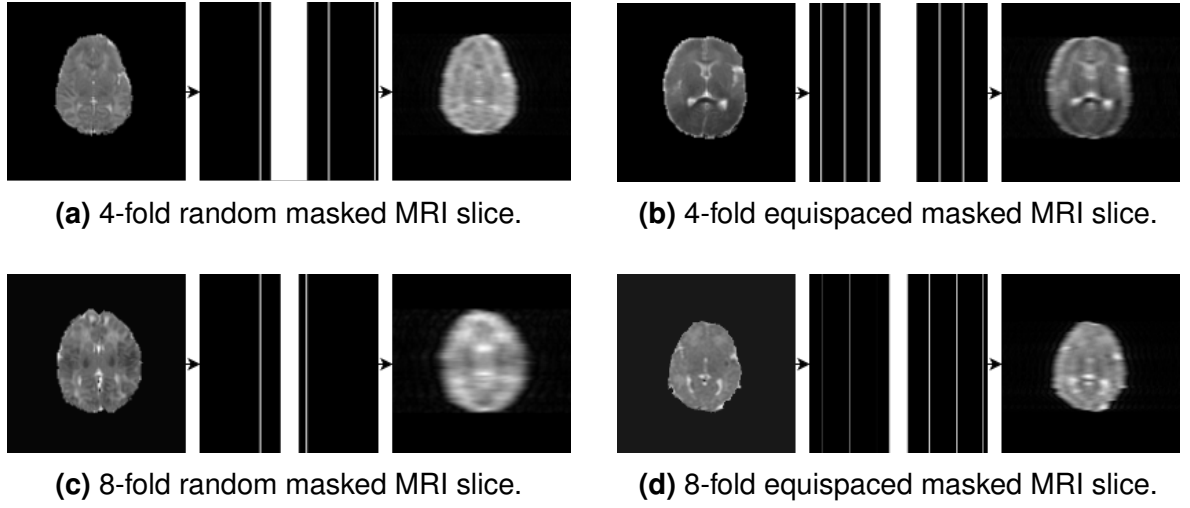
Visualization of the undersampling process with 4-fold and 8-fold random and equispaced masked MRI slices.
